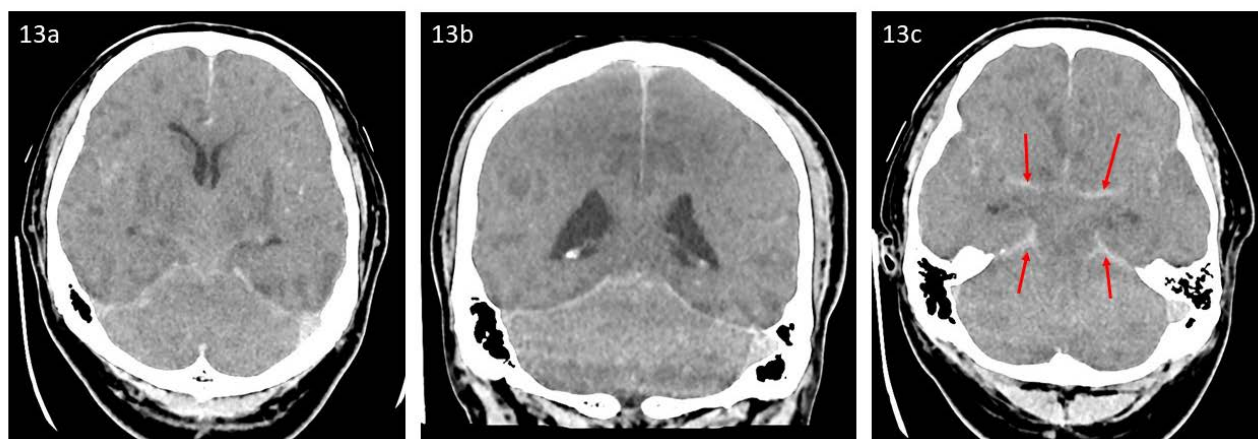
White cerebellum sign or reversal sign. 33 year old male with hypoxic ischemic encephalopathy (HIE). Axial (13a) and coronal (13b) unenhanced CT brain shows low attenuation of the cerebral hemispheres with complete loss of gray matter–white matter differentiation and effacement of the basal cisterns, suggestive of massive cerebral edema. There is relative hyperattenuation of the cerebellum compared to the supratentorial brain giving the appearance of “white cerebellum sign”. The constellation of findings are compatible with HIE. (13c) Apparent symmetrical hyperdensities (red arrows) confined to the basal cisterns are likely due to a combination of cisternal effacement, distension of vessels and relative contrast difference with the adjacent brain suggestive of “pseudo-subarachnoid hemorrhage” sign seen in HIE. GE Medical Systems Revolution CT, Slice width 3.0 mm, 140 kV, 1mAs.
